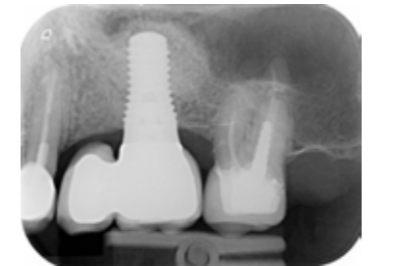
X-ray image 23 months after surgery.
